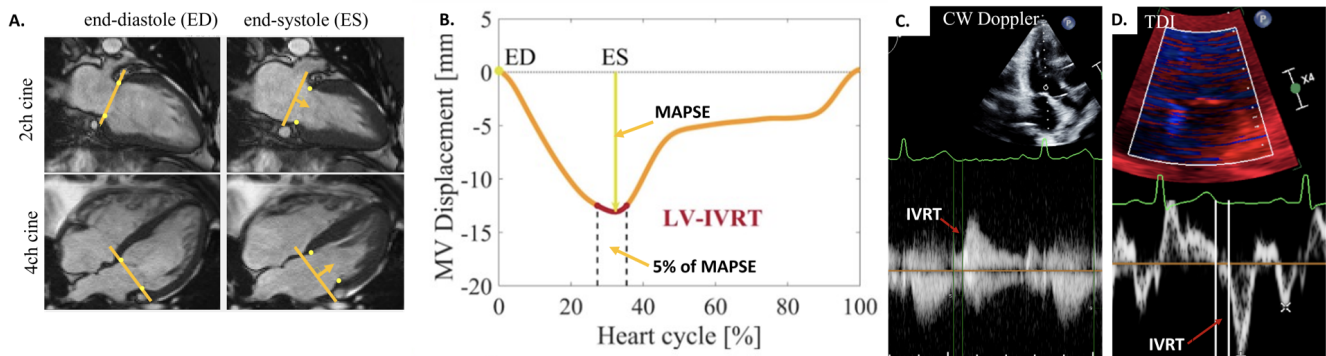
A) MRI-derived IVRT is performed by tracking the valve plane, and obtaining the valvular displacement curve, which can be used to identify MAPSE (Mitral Annular Plane Systolic Excursion). B) IVRT was defined as the time-period at end-systole during which excursion was within 5% of MAPSE. C-D) In different subjects, the IVRT is measured on CW Doppler (C) and by TDI (D).
